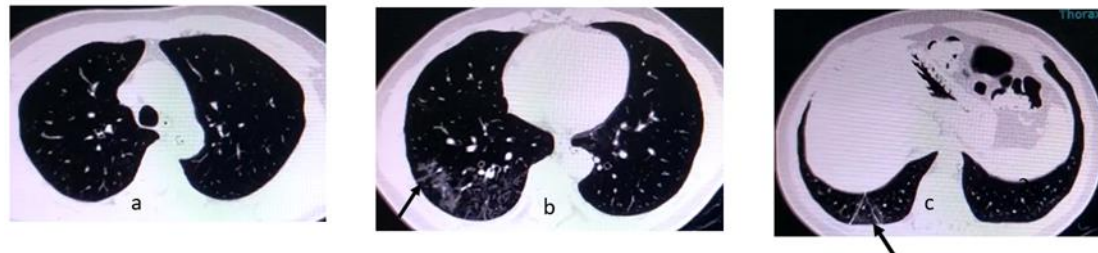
(Case 2) Follow up HRCT in 20 days from the first HRCT shows improvement. Decrease right lower GGO (b). Other lesions disappeared (a.c) suitable for convalescence stage.
